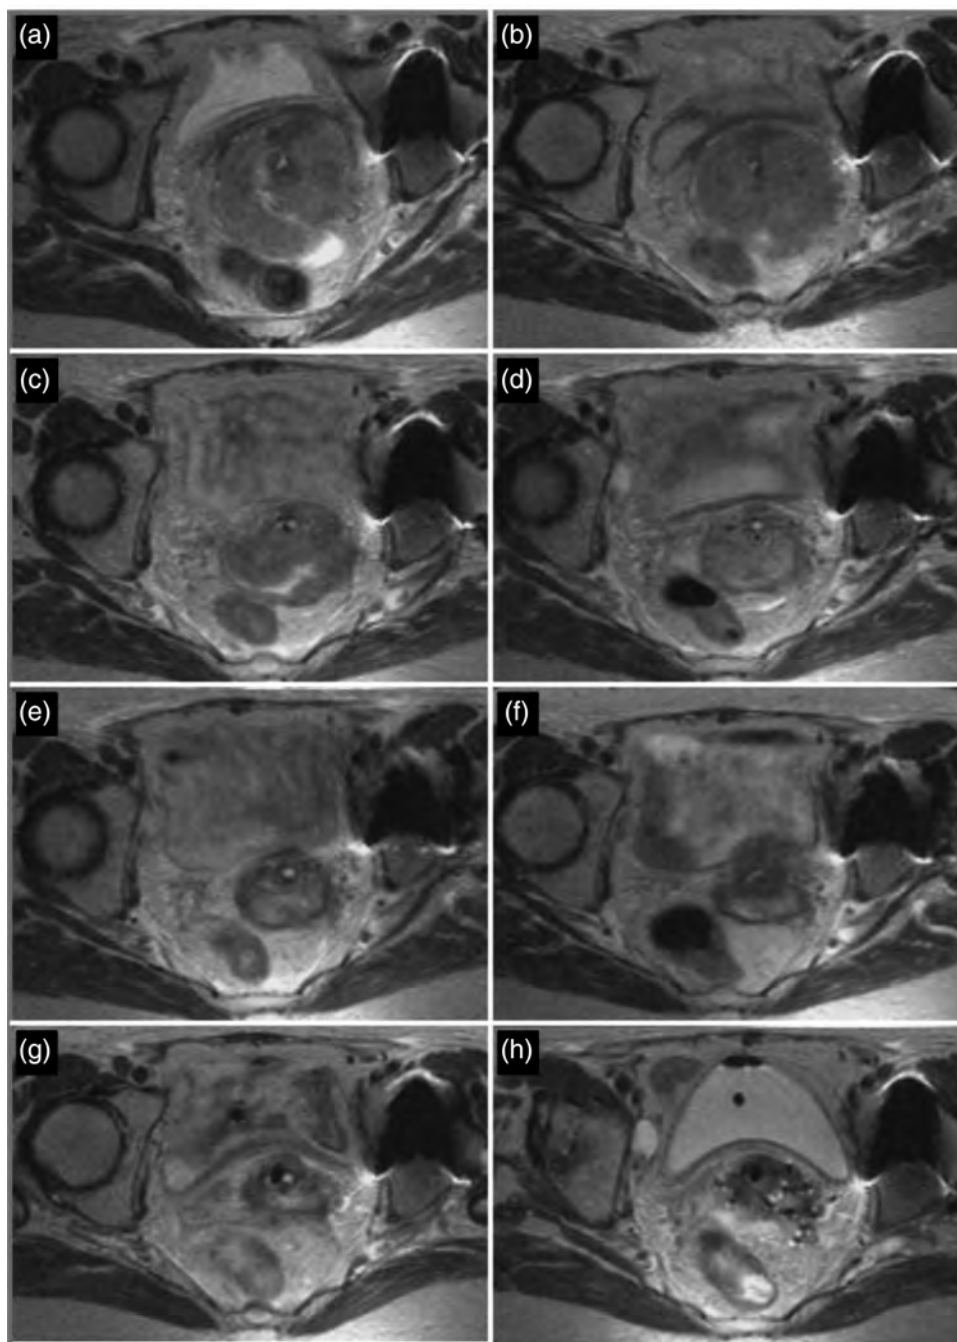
Magnetic resonance images revealing tumor regression in a patient with Stage IIIB cervical cancer during radio-chemotherapy (1.8 Gy EBRT per fraction and weekly cisplatin, 40 mg/m^2): (a) at the time of diagnosis; (b) after first week of EBRT (9 Gy)/first cisplatin; (c) after second week of EBRT (18 Gy)/second cisplatin; (d) after third week of EBRT (27 Gy)/third cisplatin; (e) after fourth week of EBRT (36 Gy)/fourth cisplatin; (f) after fifth week EBRT (45 Gy)/fifth cisplatin; (g) first intracavitary brachytherapy insertion ($D_{90} \%: 2 \times 7 \text{ Gy CTV}_{\text{HR}}$); and (h) second intracavitary/interstitial brachytherapy insertion ($D_{90}: 2 \times 8 \text{ Gy CTV}_{\text{HR}}$). The total absorbed dose in the CTV_{HR} is 90 Gy ($\text{EQD}_{2_{10}}$) (see Sections 2, 5, 7, and 8 for explanation of terms).
